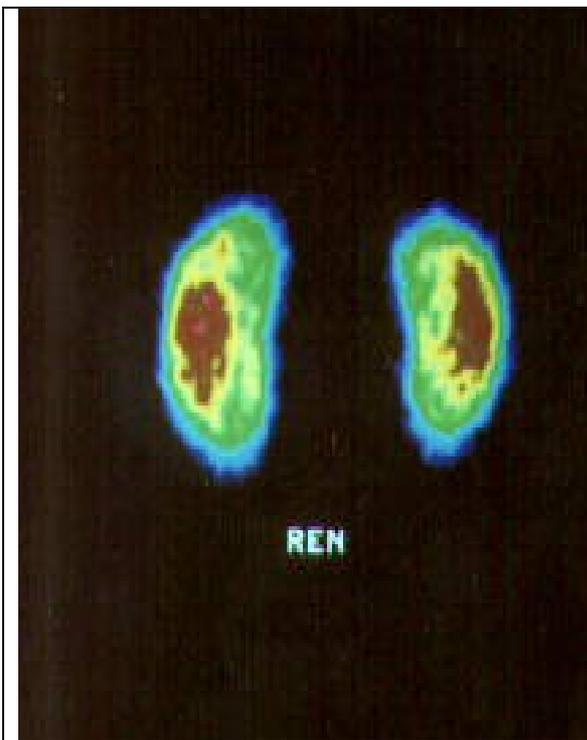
Angyonephrosintigraphy Static scintigraphy of kidneys with ^{99m}Tc - DMSA. Accumulation ^{99m}Tc - DMSA by both kidneys intensive enough and uniform. Both kidneys of the usual form, the sizes and a position. Norm.
